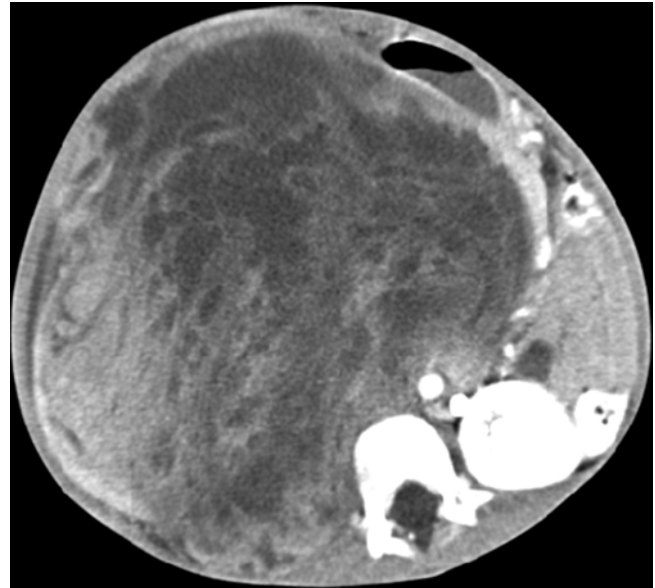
Axial CT image of patient presenting with right sided Wilms' tumour causing duodenal obstruction
